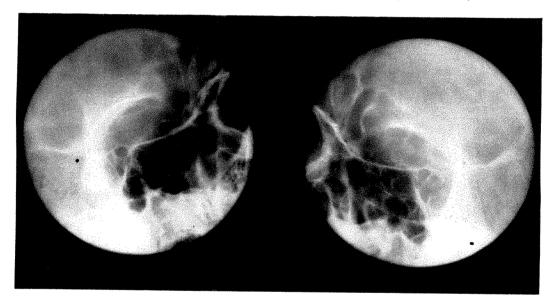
Roentgenogram showing both canals and some of the accessory sinuses.
